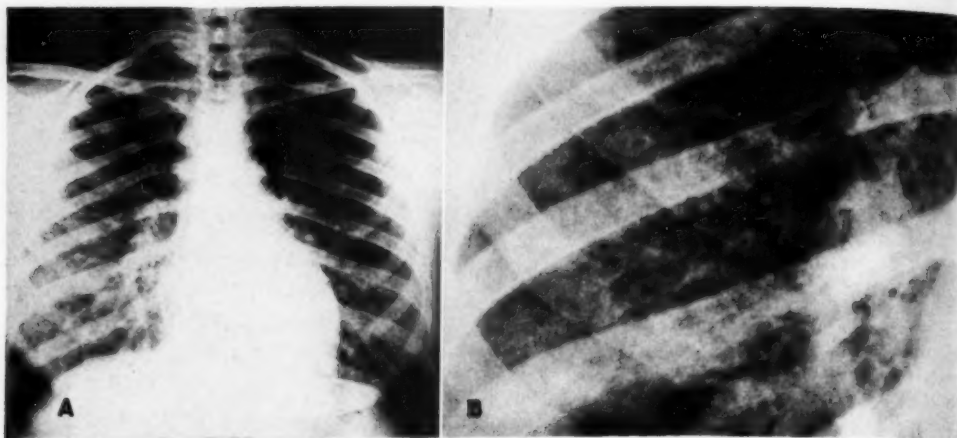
Case 9: Sarcoidosis. Granular, pseudo-miliary pulmonary infiltrate developing relatively late in the disease. White, female, 17, who, six years and a half previously, had bilateral hilar and right paratracheal adenopathy. Positive skin biopsy. See case report in text for details of serial roentgen examinations, etc. B. Detail view of granular infiltrate (pseudo-miliary).
